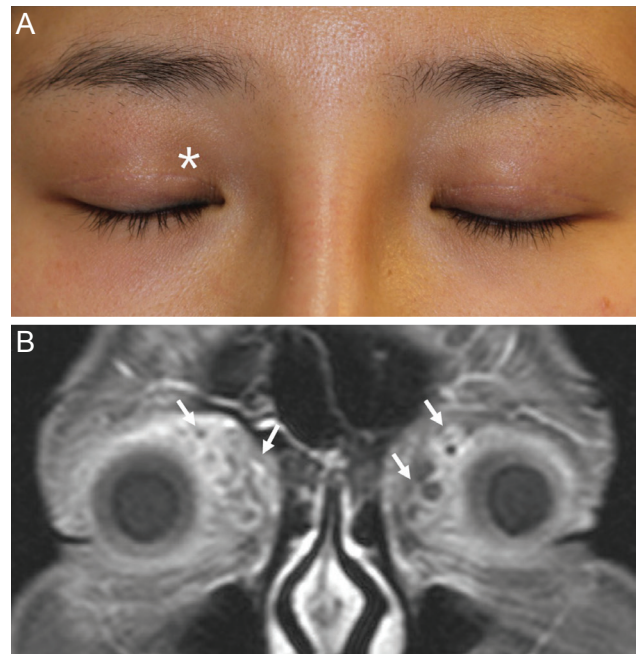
(A) A 31-year-old woman presenting with a 3-week history of palpable mass in the right upper eyelid (asterisk) that developed 7 months after an injection of cryopreserved autologous fat into her forehead. (B) A T2-weighted coronal image reveals multiple lesions (arrows) of heterogeneous high signal intensity in both upper eyelids.
